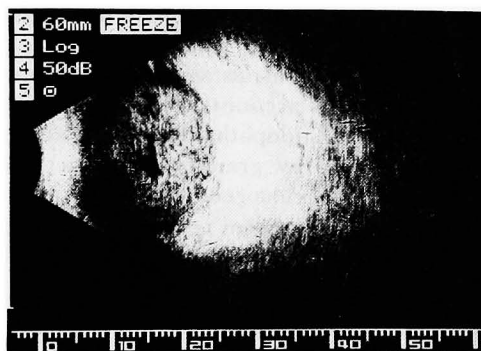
Ultrasound findings of left eye. Dense vitreous opacity was increased severely, and a hypopyon was present in the anterior chamber.
